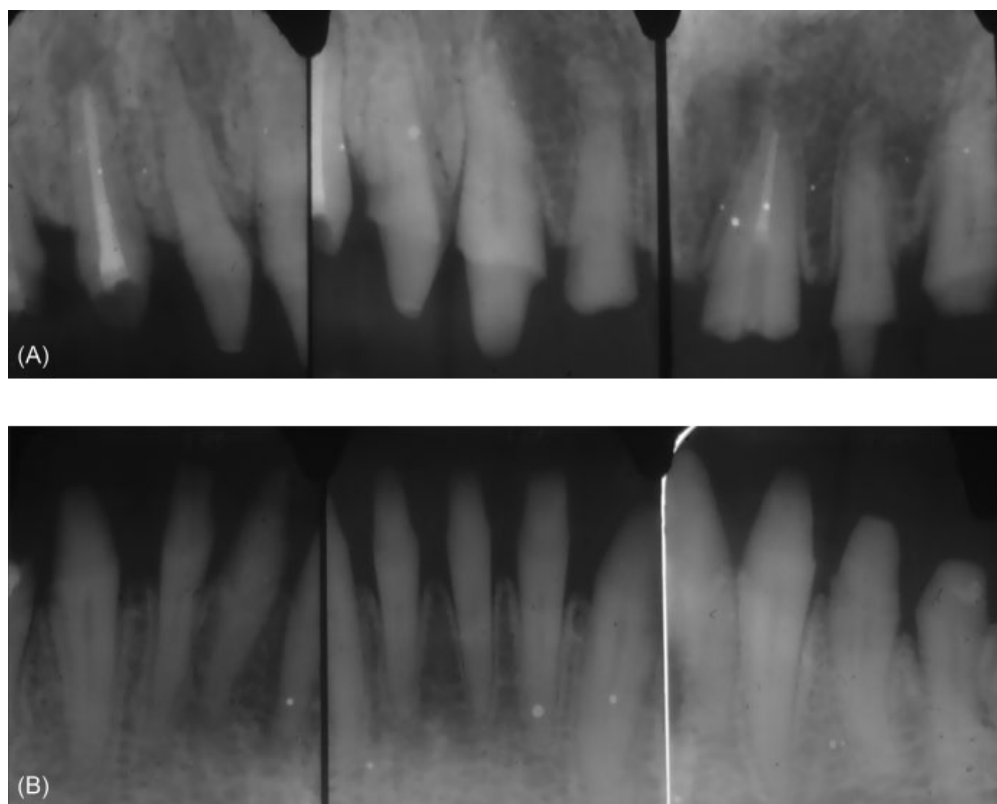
(A, B) Precementation radiographs provide a road map to the canals if endodontic therapy is necessary after cementation of the castings. *Source:* Courtesy of Dr Henry Yamada.
